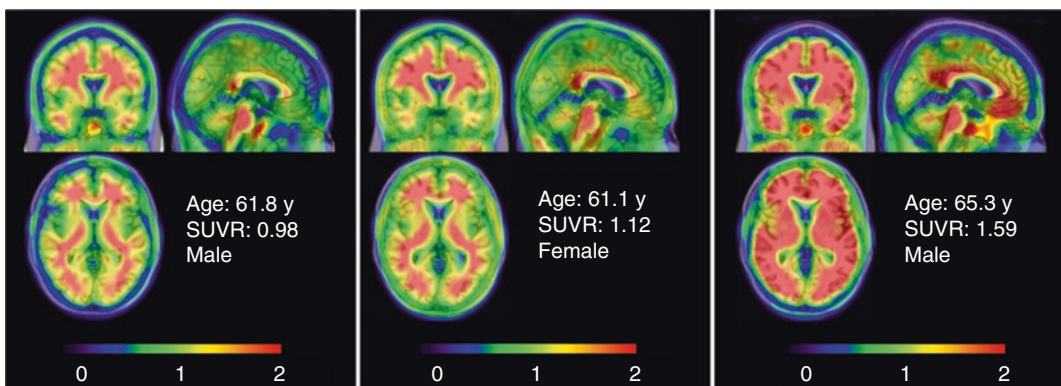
Florbetapir-PET imaging of AD patients. The horizontal bar represents the range of the ratio of cortical to cerebellar signal scores (i.e., SUVR) in semi-automatic
